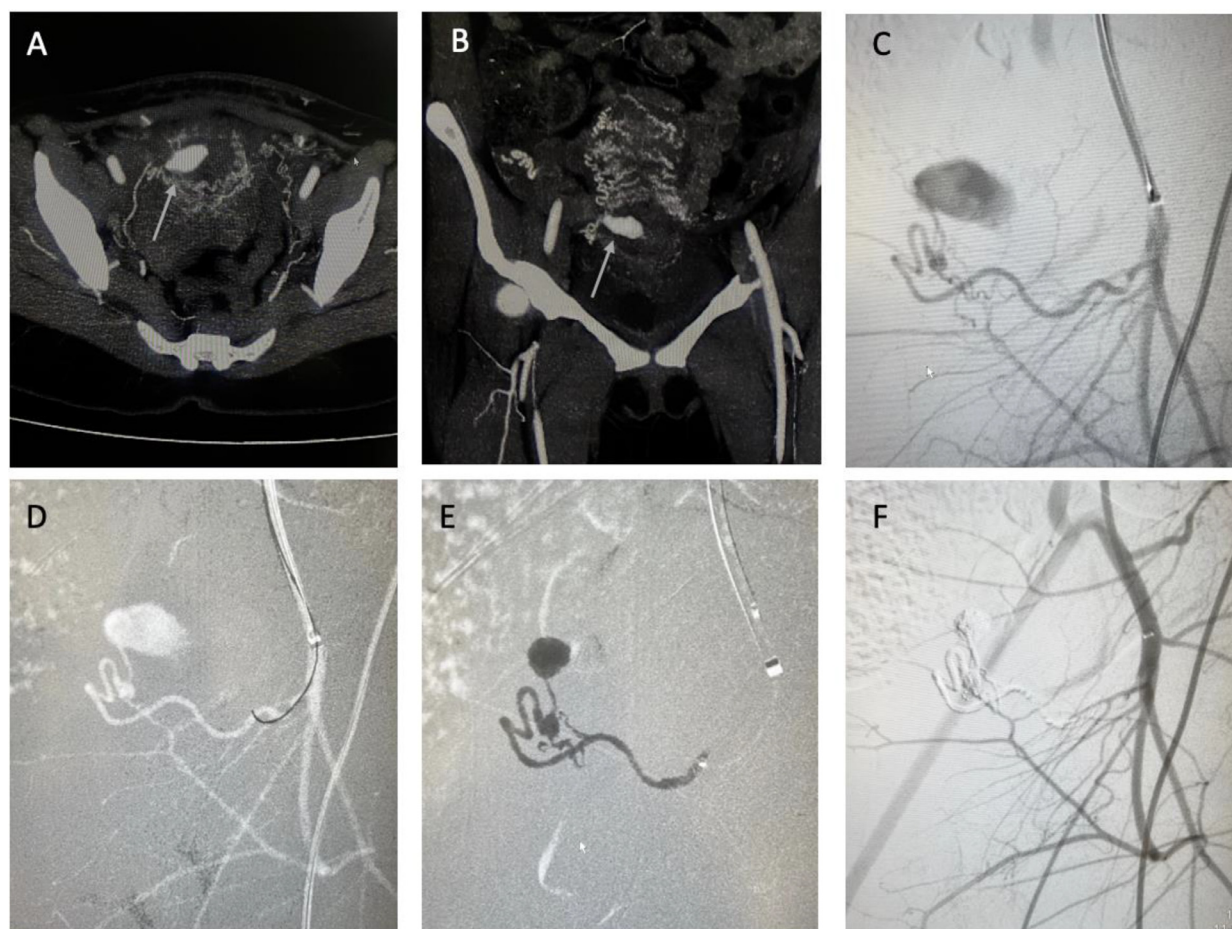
(A and B) CTA abdomen and pelvis axial and coronal images showing pseudoaneurysm (white arrow) in right lateral uterine wall (C) 2D right internal iliac angiogram showing uterine artery pseudoaneurysm (D) 2D roadmap showing navigation into the smaller branch. (E) Roadmap image showing microcatheter 30% glue cast (F) 2D right internal iliac artery angiogram showing complete obliteration of pseudoaneurysm with normal filling of other branches.
